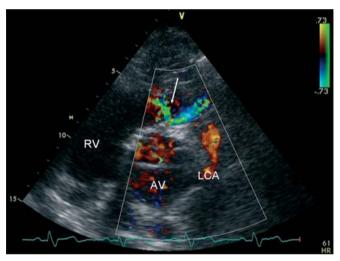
Transthoracic echocardiogram, parasternal short axis. Diastolic Doppler flow signal in the right ventricular outflow tract originating from a coronary fistula (arrow). AV=aortic valve, RV=right ventricle, LCA=left coronary artery.
